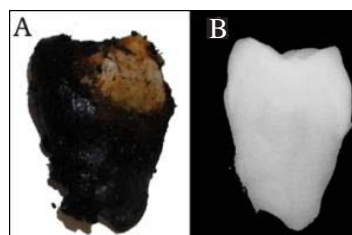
Comparison between post-mortem macroscopic (A) and radiographic (B) morphology of the tooth #18.
